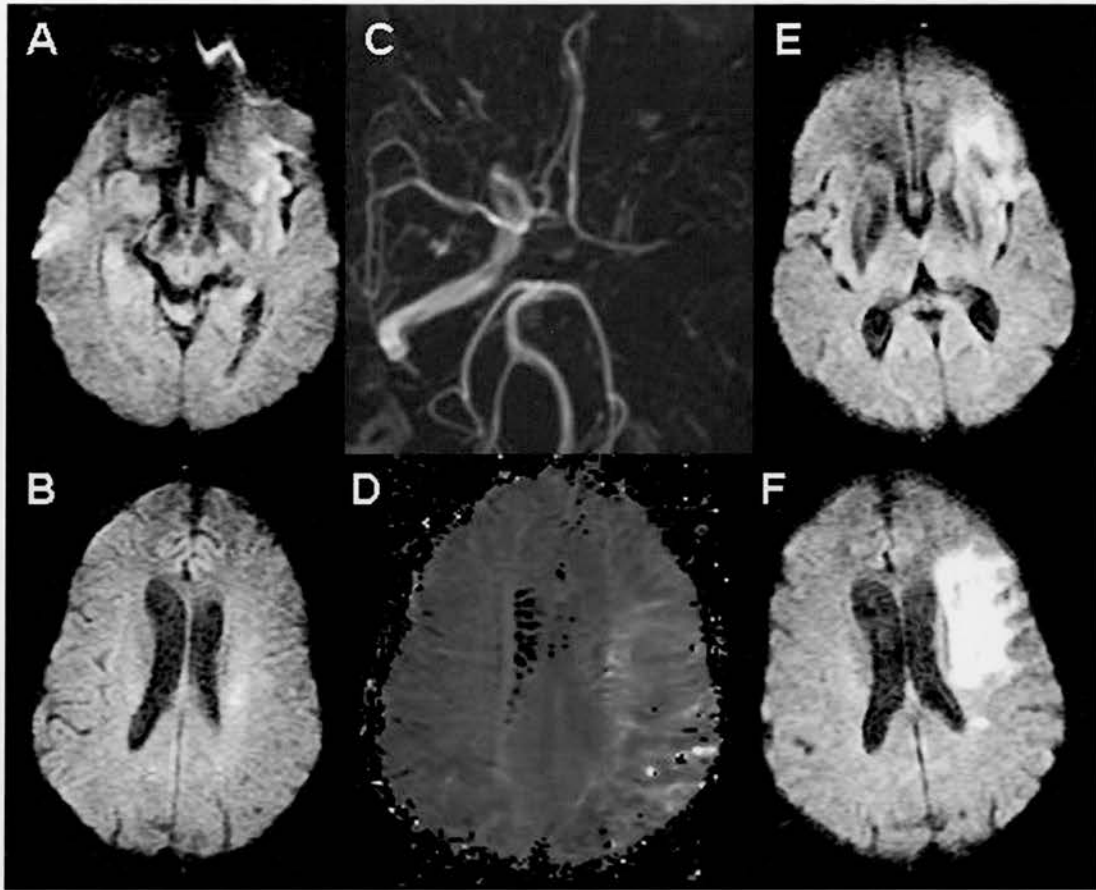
A, B, C and D show the baseline MRI of a 79 year old female with a left ICA and M1 occlusion, with initially a small DWI lesion. She presented with a baseline NIHSS of 2 consisting of mild right sided weakness and progressed to severe right hemiparesis. 12 hours after admission to hospital. The MTT map showed only a mild MTT abnormality, but it was larger than the DWI lesion. E and F show the 30day DWI scan with a new DWI lesion in the same vascular territory, but outside the original perfusion abnormality.
